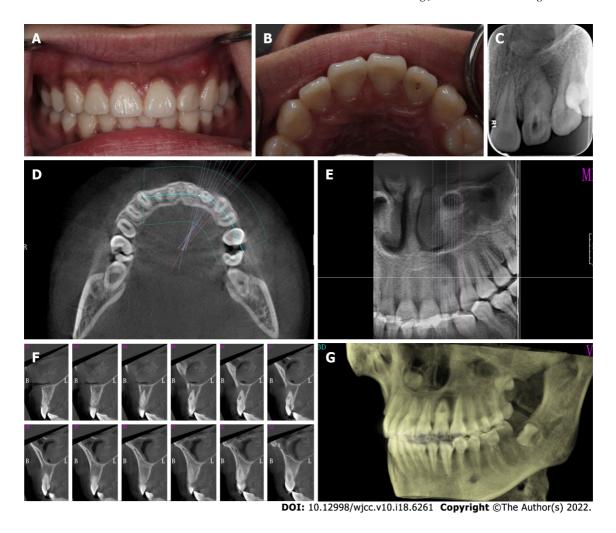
Preoperative photograph of the left upper anterior teeth. A: Labial view showing an intact left lateral incisor with a sinus on the distobuccal aspect; B: Palatal view showing tooth 22 with an access cavity; C: Radiograph showing the presence of dens invaginatus (DI) associated with a large periapical lesion; D-F: Cone-beam computed tomography images: Transverse view showing radiolucency surrounding tooth 22 (D), coronal view showing a DI extending to the apex of the root (E), and sagittal sections showing DI with a large periapical radiolucency (F); G: Three-dimensional reconstruction indicating loss of labial cortical plate.
